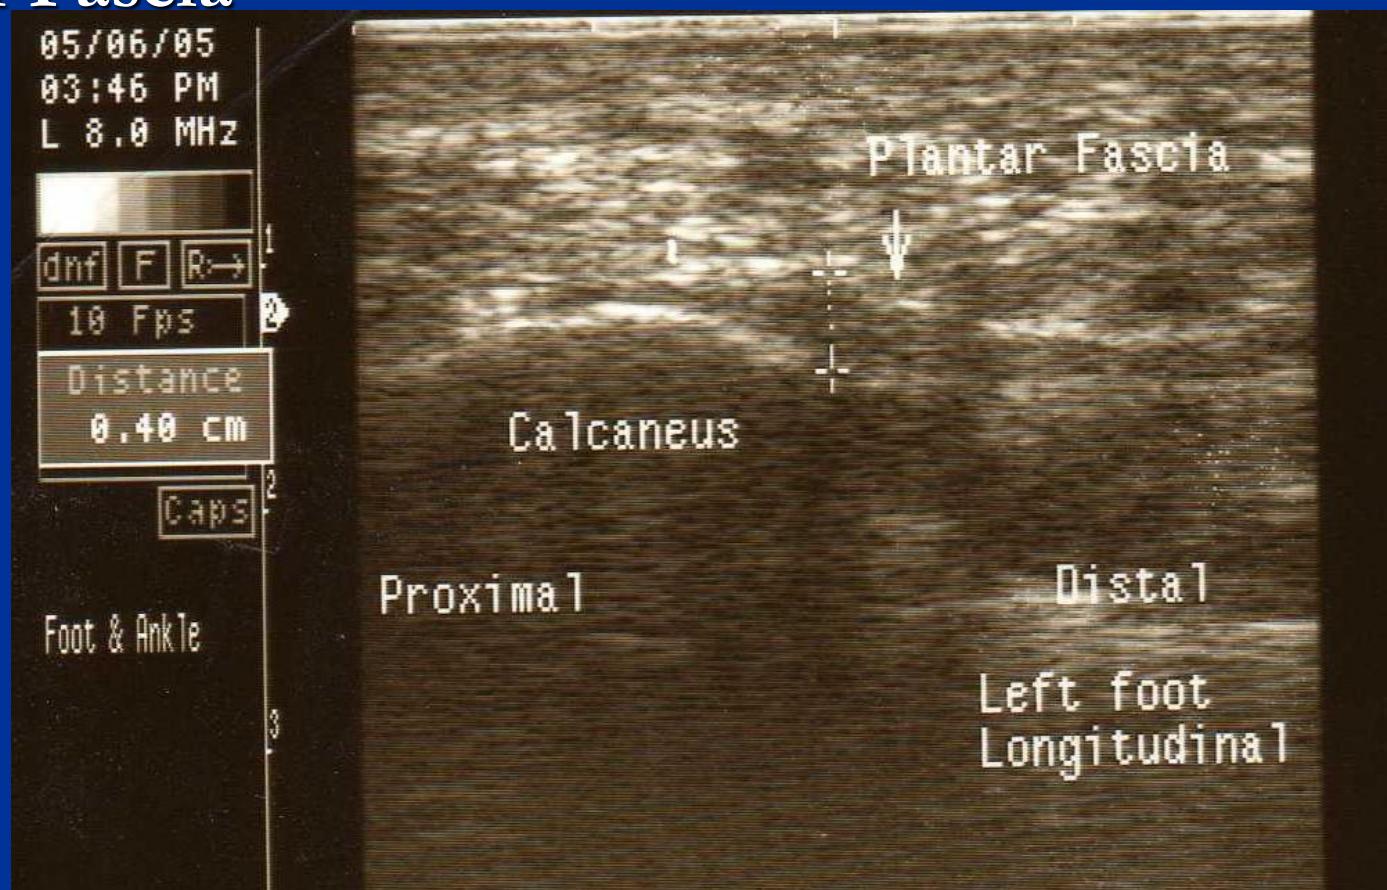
Site of measurement for quantitative analysis of changes at the plantar aponeurosis origin. LS sagittal ultrasound image, inferior calcaneal region, plantar aspect of foot. The normal internal longitudinal fibrillar pattern is clearly demonstrated within the plantar aponeurosis (fascia) origin (*P*). The plantar aponeurosis thickness (x-x) is measured at a point where it crosses the anterior-inferior border of the calcaneus (*C*)
